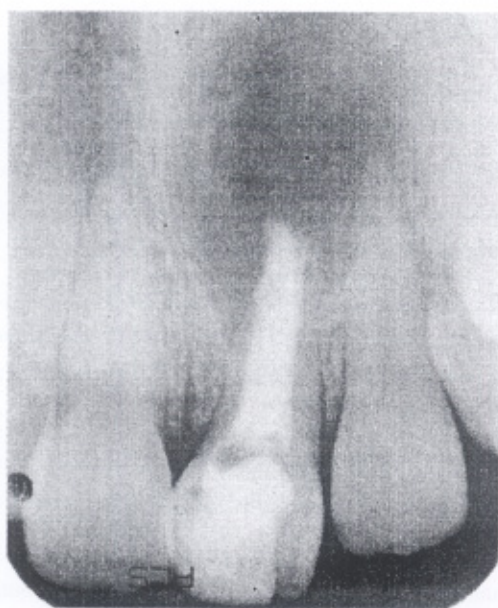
Radiograph taken after the application of the calcium hydroxide, when the patient showed-up after two years. Note the size of the periapical lesion.
